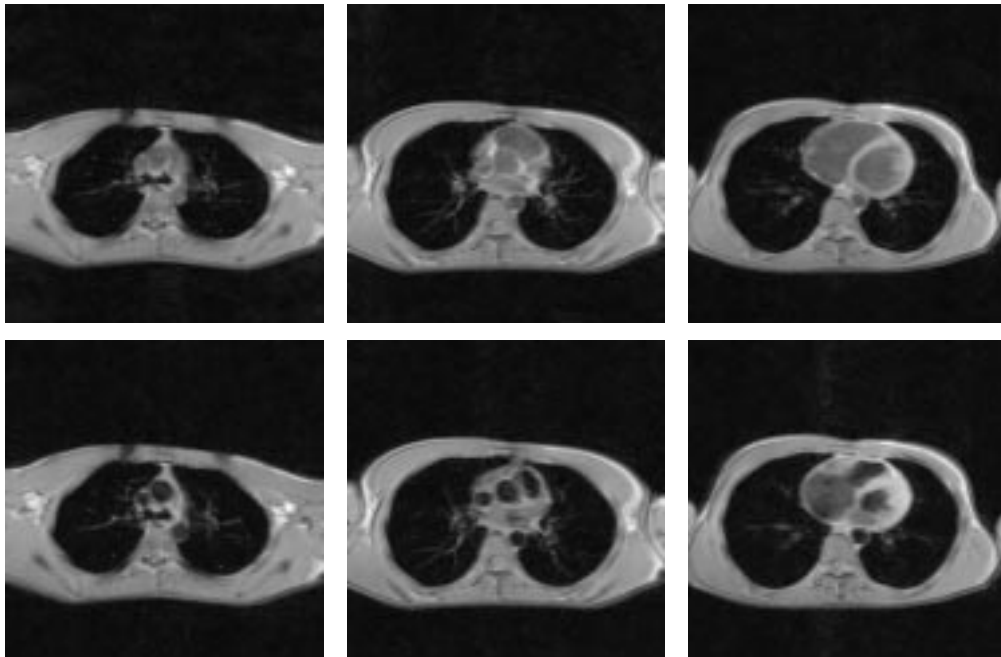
Examples of transverse dark-blood images extracted from the 4D MRI dataset. (Top line: parallel spatial slice locations; bottom line: other temporal slice locations for corresponding slices)
